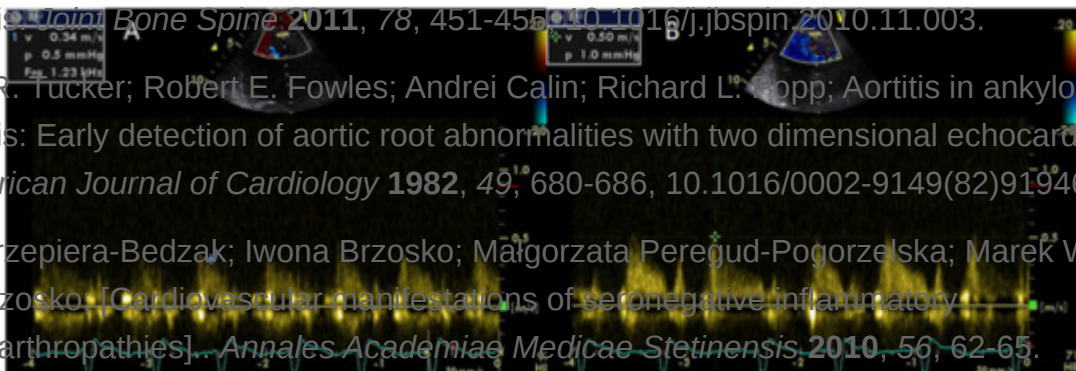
A patient with rheumatoid arthritis and impaired coronary flow reserve by Doppler echo. Coronary flow of the left anterior descending artery (LAD) at rest (A) and after adenosine infusion (B). Coronary flow reserve as a
